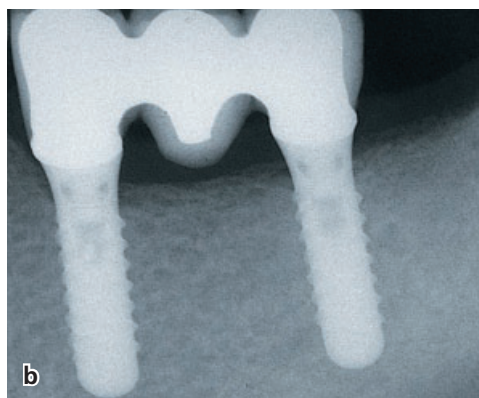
(a) Occlusal view of a cemented three-unit metal-ceramic FPD, supported by a mesial and a distal implant. (b) The corresponding 3-year follow-up radiograph confirms stable conditions at the implant to bone interface of the two 12 mm solid screw implants.
